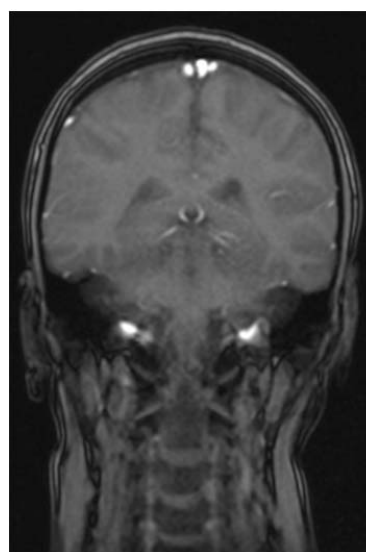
Special MR image of brain
